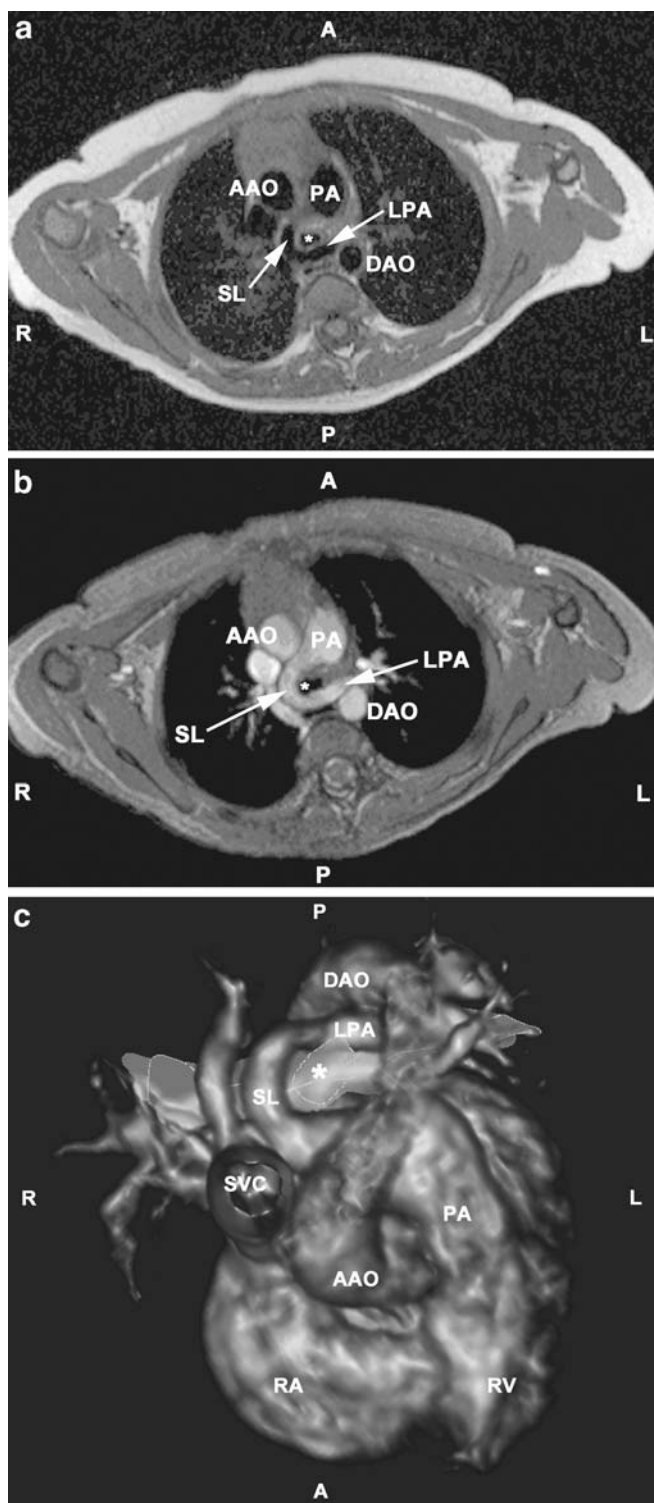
A 2-year-old patient. a Axial T1-weighted spin-echo image (2-mm slice thickness) shows a pulmonary artery sling of the left pulmonary artery. b Angulated MIP of the pulmonary artery sling (3D FISP MRA). c A 3D volume-rendered model based on a 3D FISP MRA dataset. The tracheo-bronchial tree is coloured blue. (A anterior, P posterior, L left, R right, LPA left pulmonary artery, AAO ascending aorta, DAO descending aorta, PA pulmonary artery, SL pulmonary artery sling, RA right atrium, RV right ventricle, SVC superior vena cava, asterisks trachea)
